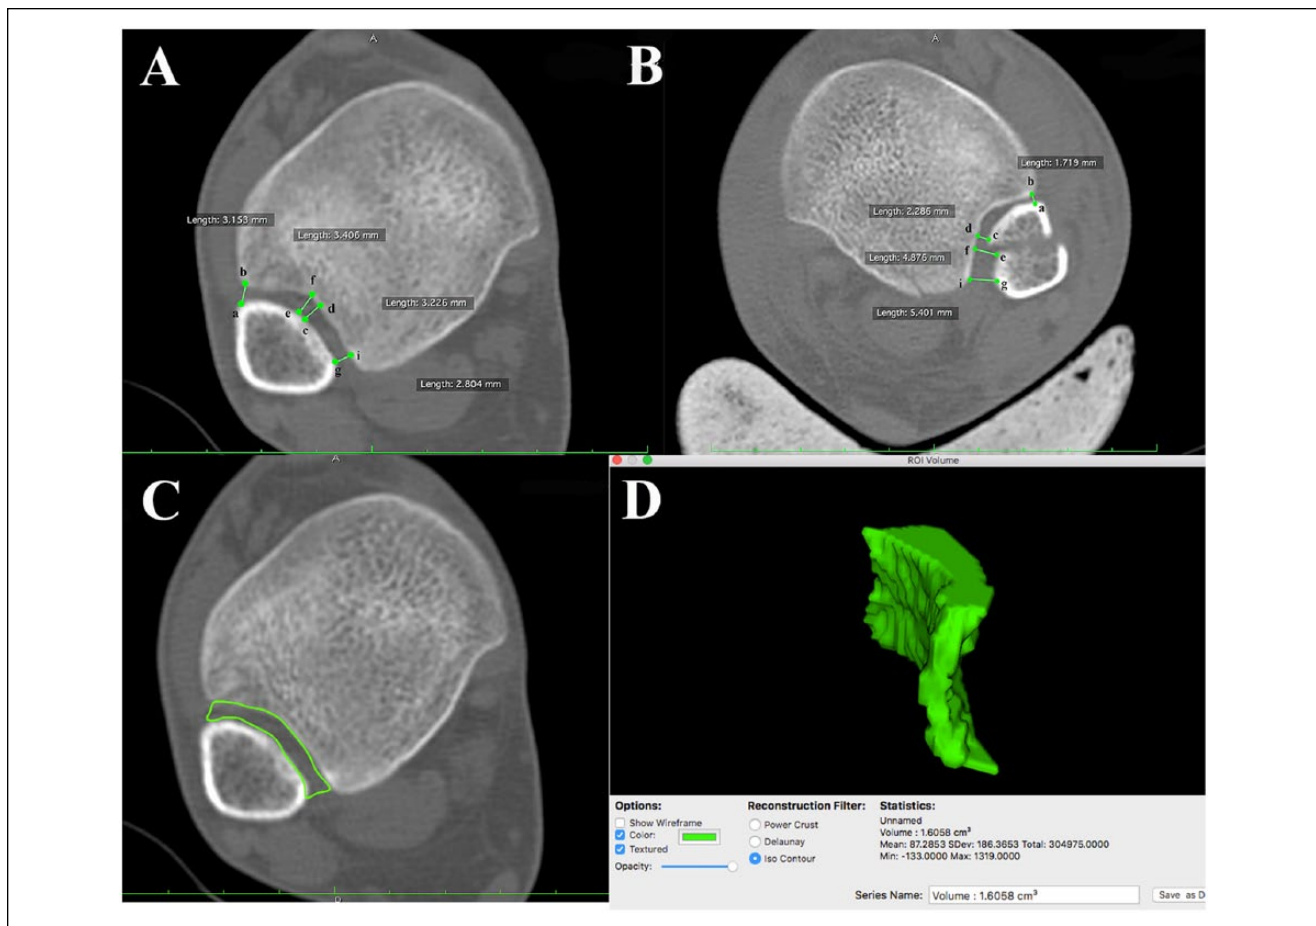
Measurement of (a-b) anterior, (c-d) middle, (e-f) maximal and (g-i) posterior tibiofibular distances in the (A) normal and the (B) fractured ankles. (C) To calculate the volume of the syndesmotomic joint; the margin of the syndesmotomic area was drawn on axial CT images. (D) Then, the volume was computed automatically by the program.
